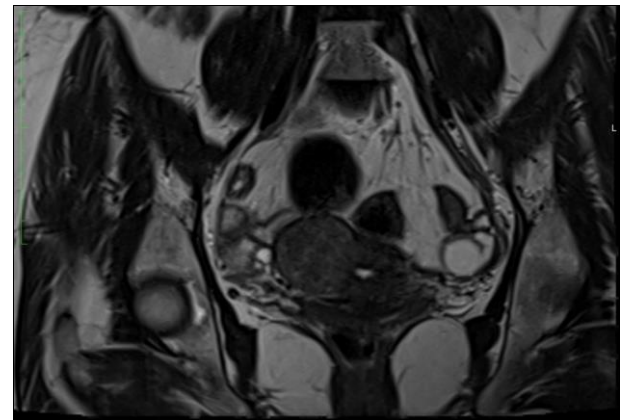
T2 weighted MRI image of the same patient showing well defined, heterogeneous lesion with mass effect.
